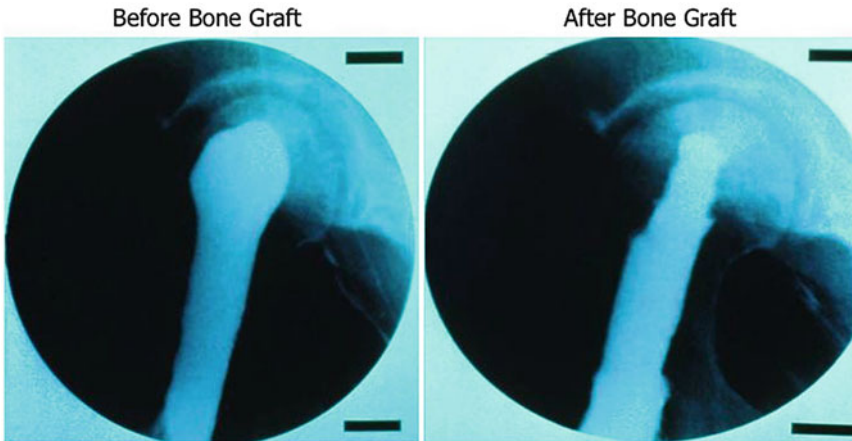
Radiographic contrast medium is reinjected to confirm adequate bone grafting of the cavity defect
